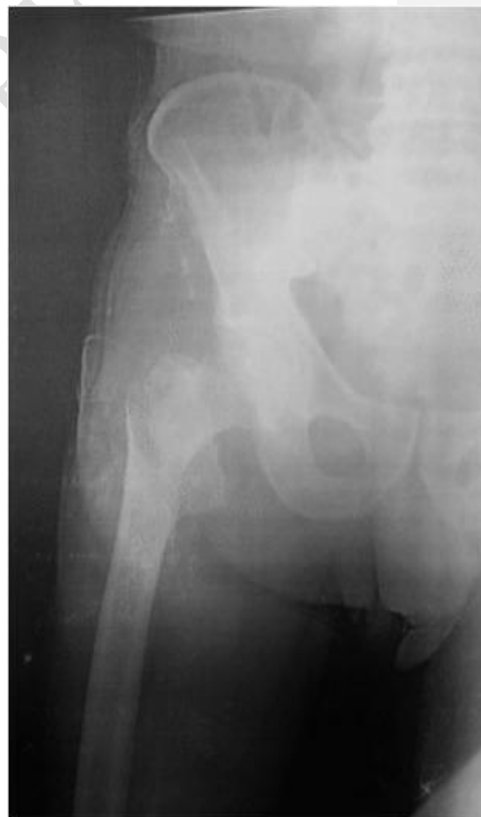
Xray image in supine position
